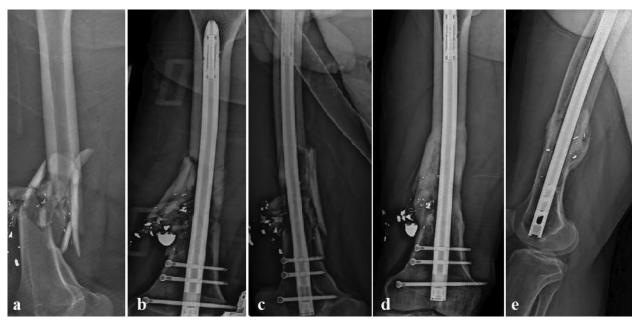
(a), Preoperative radiographof a 38-year-old man with type A3 open distal third femoral fracture; (b and c) early postoperative radiograph of distal third femoral fracture managed by Talon distal fix nail; (d and e) Follow up radiograph at 18 weeks showing fracture consolidation
